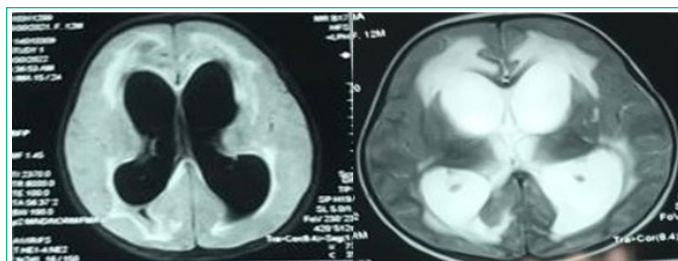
(a) Axial T1-weighted image with dilated lateral ventricles. (b) Axial T2-weighted image with dilated lateral ventricles.
